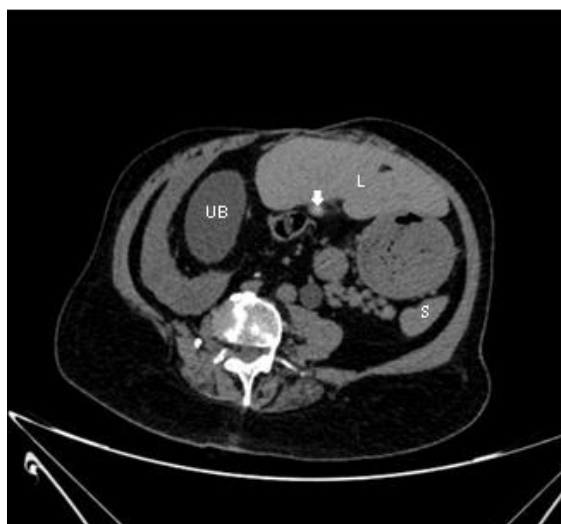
CT Abdomen showing displaced displaced spleen (S), liver (L), urinary bladder (UB) and GB (indicated by white arrow) with features of acute calculous cholecystitis.
